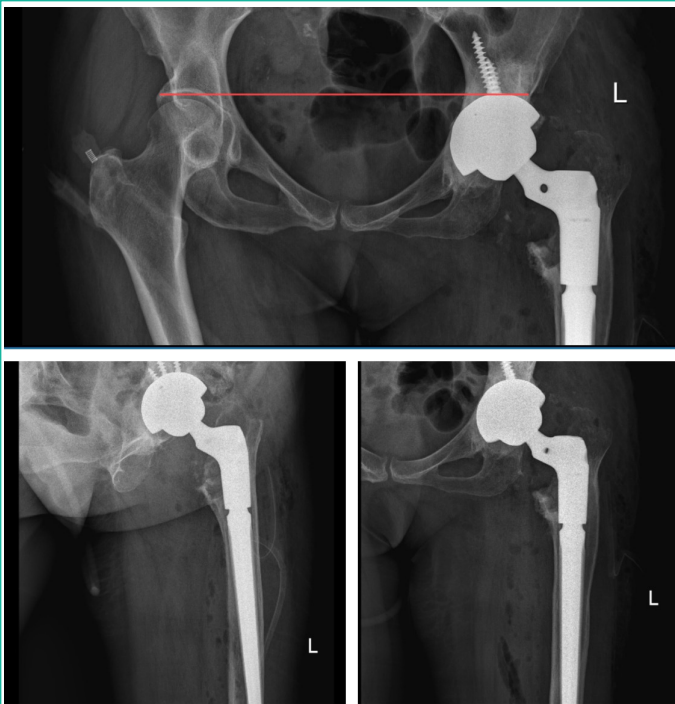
The X-ray confirmed that the surgical hardware was well positioned after implantation.
